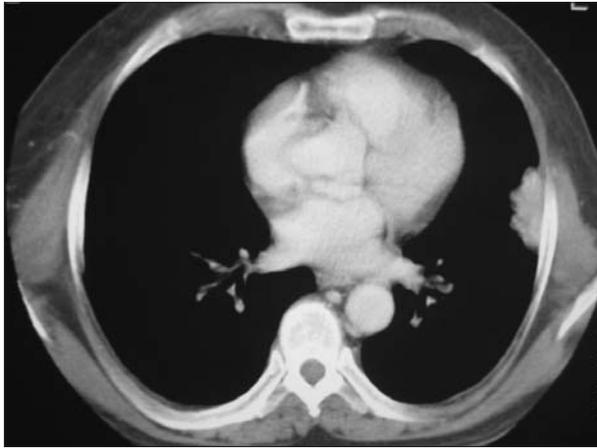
Pre-op. CT scan with iodized non ionic contrast medium showing a 3 cm in diameter nodular shadow in the upper segment of the lingula abutting the pleura, with irregular border and light hyperdensity.
